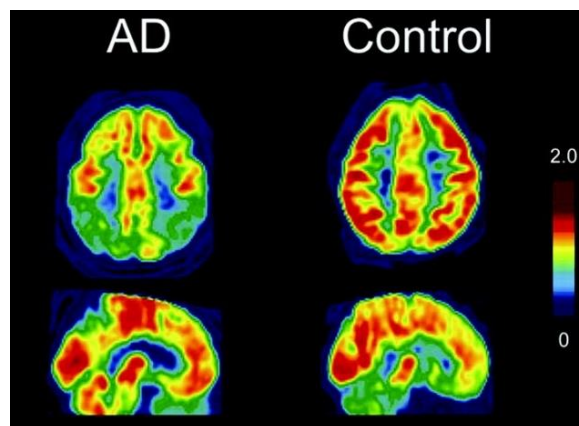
Glucose hypometabolism in the brain of mild-AD patient. Fluorodeoxyglucose (FDG)-positron emission tomography (PET) images of a normal control subject and a patient with AD with severe hypometabolism (yellow and blue cortical regions) (Boxer et al., 2007).
